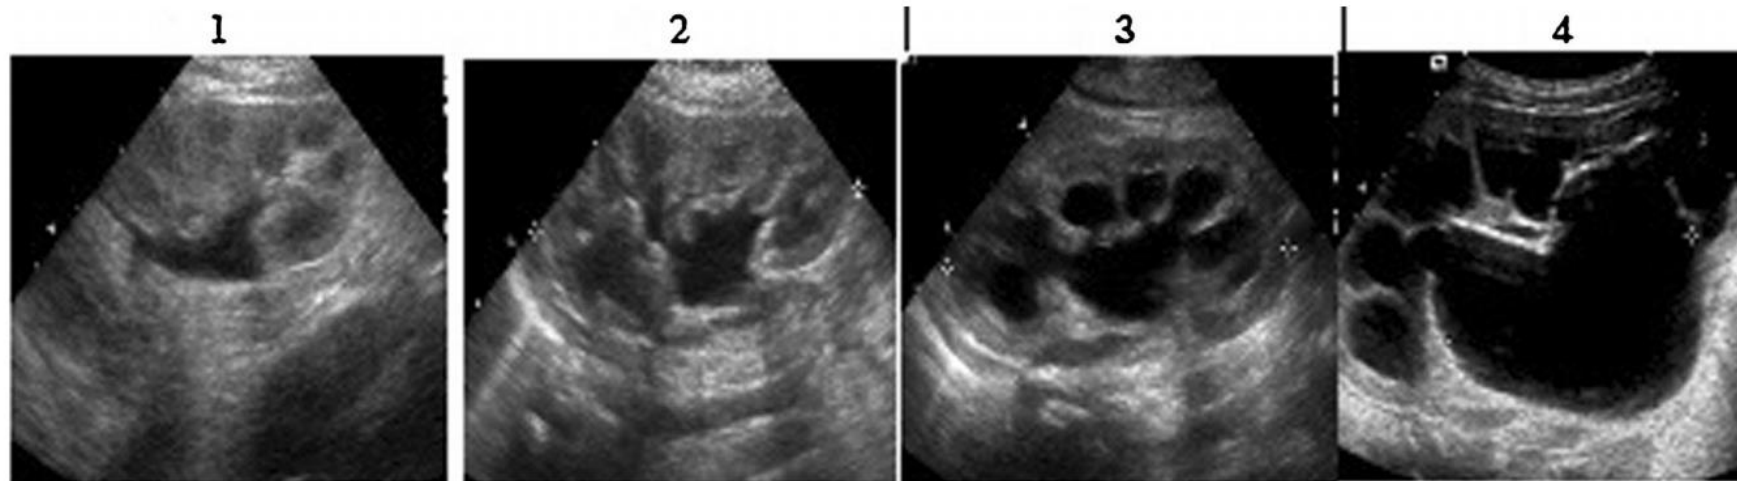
Ultrasound appearance of hydronephrosis by Society for Fetal Urology (SFU) classification
